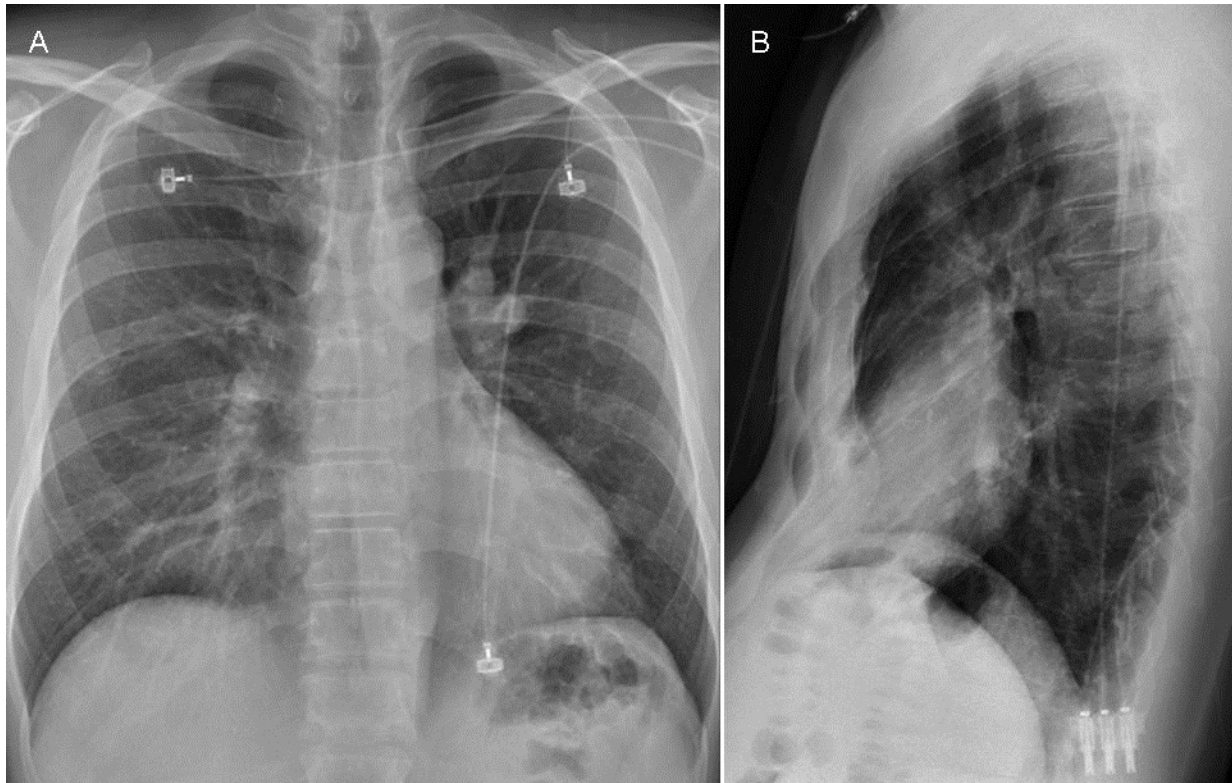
Frontal and lateral chest radiography shows a lobulated, circumscribed lesion within the left hilum. The right hilum appears normal, no lung consolidation is present, and no pleural abnormalities are seen. There is no evidence of mediastinal lymph node enlargement. There is relative lucency involving the left lung, particularly the left upper lobe, compared with the right side.
